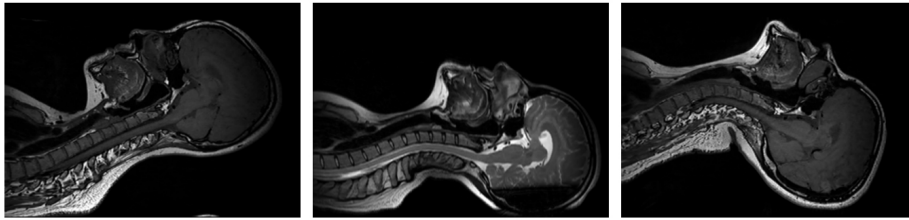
The MRI scan results with a sagittal view of (a) flexion posture with physical support under the head; (b) neutral posture with a small pillow under the neck position; (c) extension posture with physical support under the shoulder and neck position.
